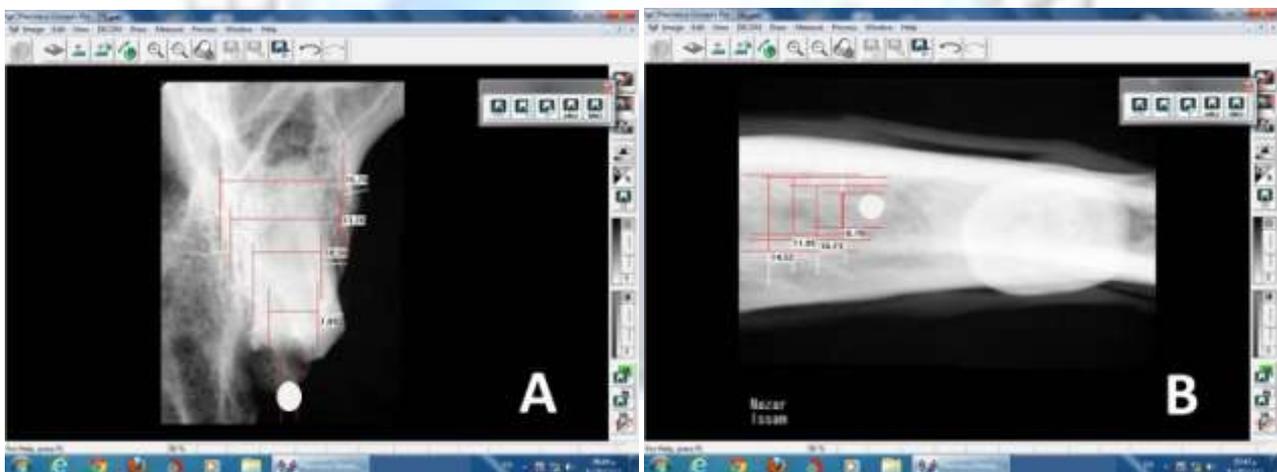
Radiographic measurements of the alveolar bone thickness projected by Longitudinal Topographic Occlusal Projection. A- Maxilla. B- Mandible.
